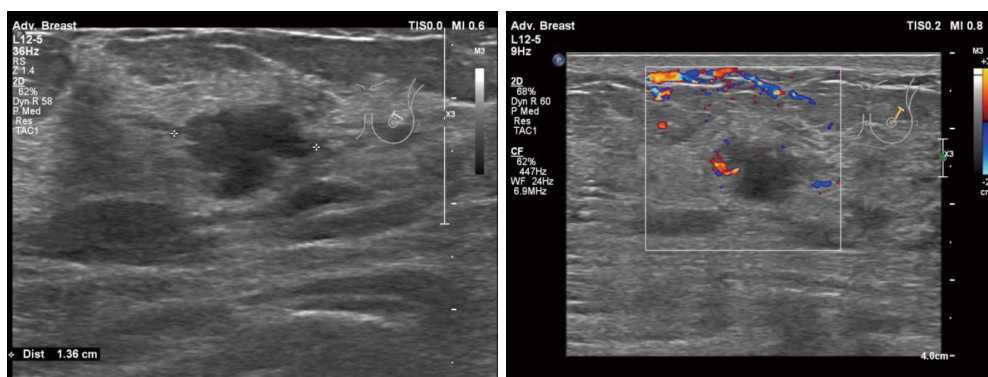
Mammary ultrasound examination results.
